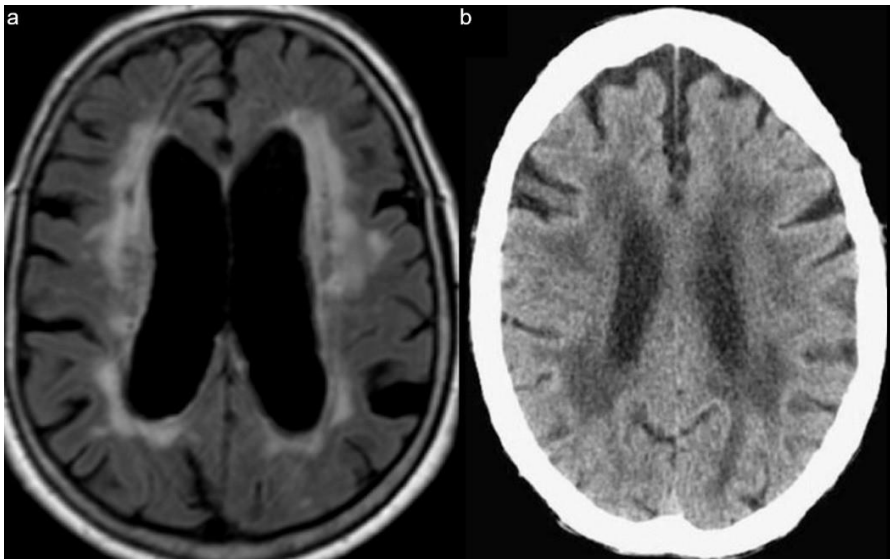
An example of white matter lesions (WMLs) on FLAIR-MRI (a) and CT (b).
